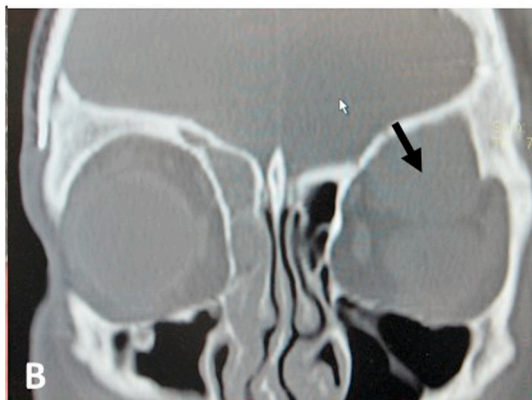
Coronal CT scan showing large orbital cystic lesion in the left superior orbit and the frontal sinus. The lesion is marked with black arrow.
